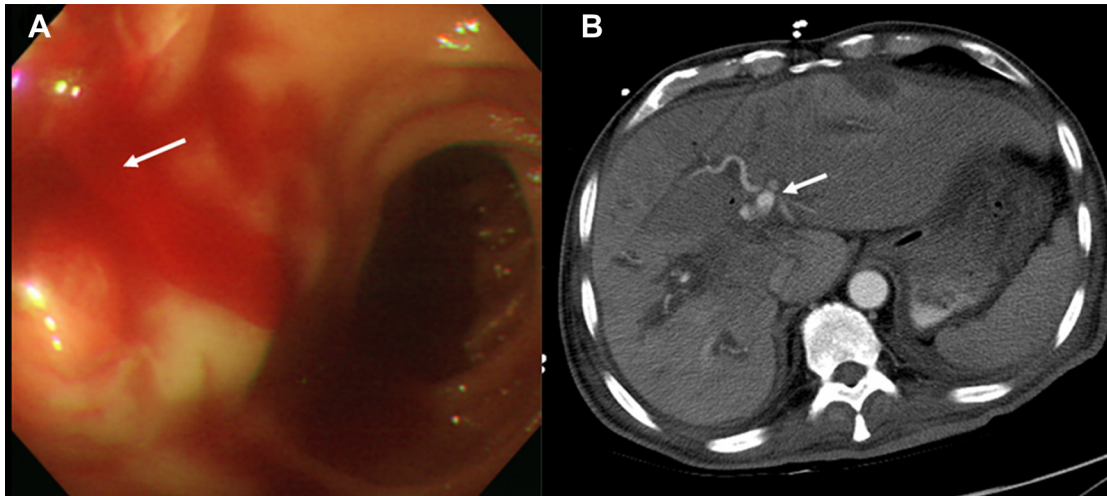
(A) Upper gastrointestinal endoscopy reveals active bleeding from the papilla as hemobilia. (B) Computed tomography shows one sacular lesion with contrast enhancement without extravasation (white arrows).
